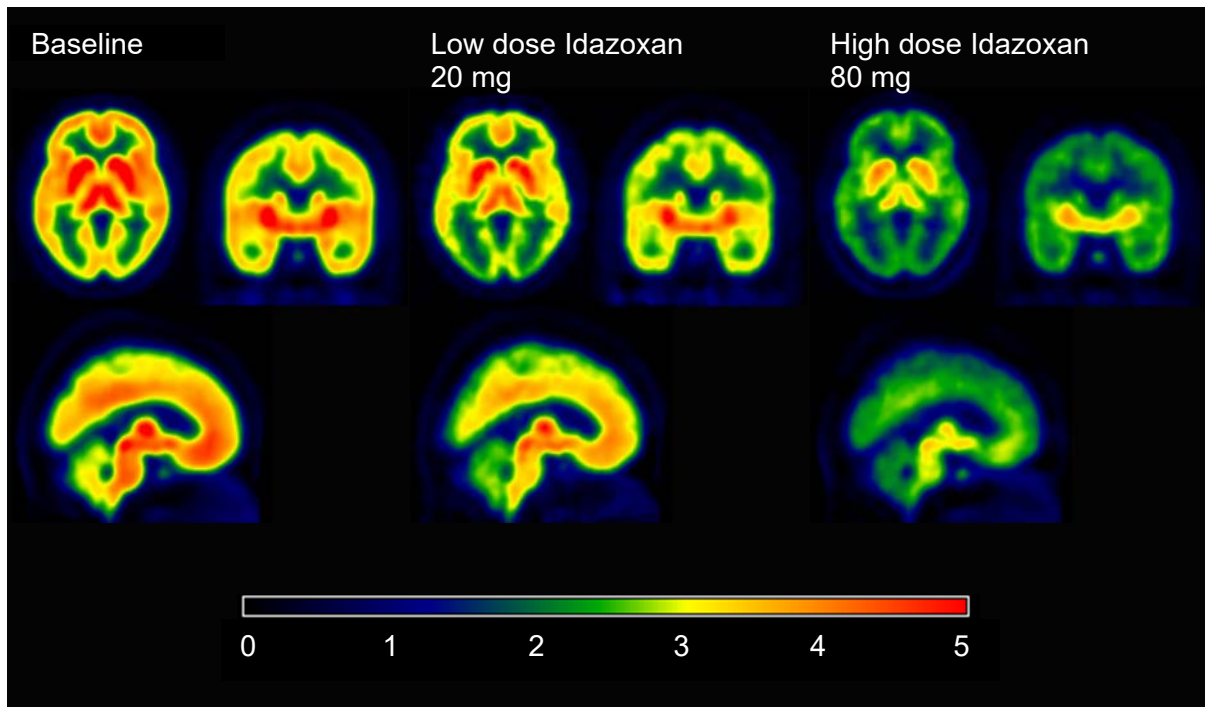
SUV images to demonstrate brain heterogeneous brain uptake in all regions and a dose-dependent blockade by idazoxan.
